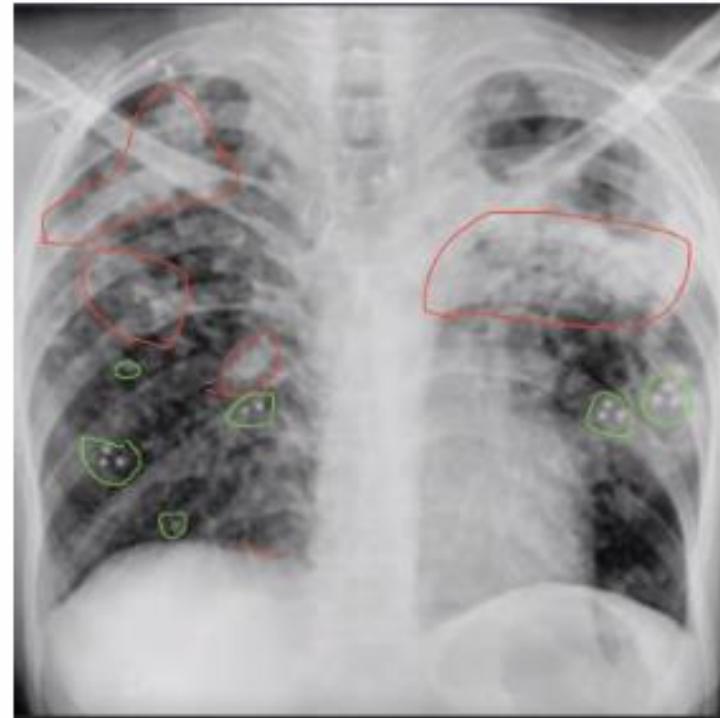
SME Evaluation of TB X-ray (left) vs Grad-CAM with VGG16 (right)
